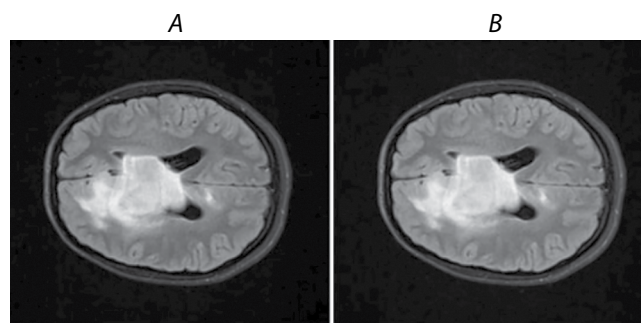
Diffuse glioma (T2-FLAIR, ax).
